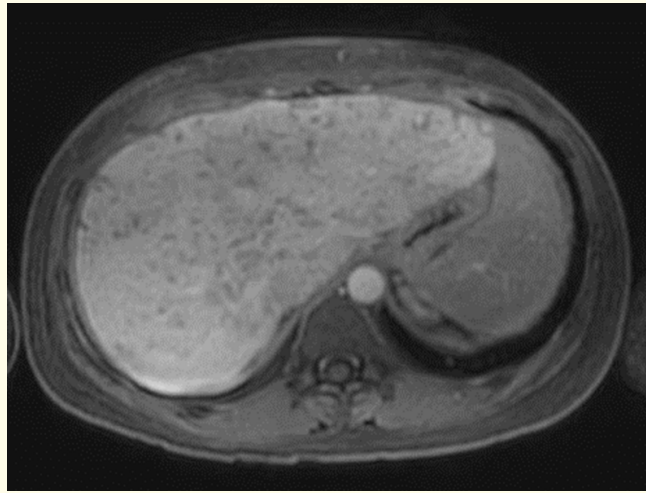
MRI T1 weight image showing liver parenchyma with a diffuse heterogeneous signal and reticular areas.
